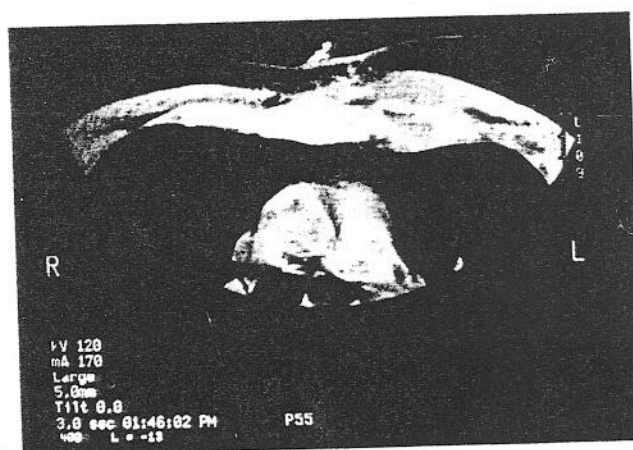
Chest CT scan of a 33-year-old man showing osteomyelitis of the left 2nd costal cartilage due to *Salmonella*.
